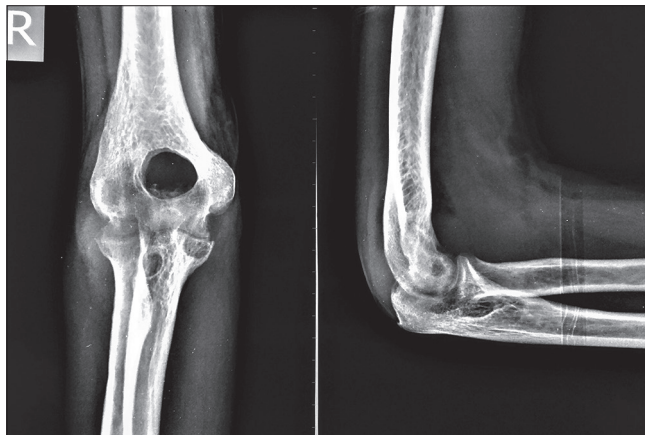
The elbow radiograph shows a round hole created by the enlarged coronoid (or olecranon) fossa by the disease process, along with a poorly defined joint outline and regional osteopenia. Two eccentric lytic lesions are appreciated in the proximal ulna, and a hazy olecranon tip can be seen within the round hole.
